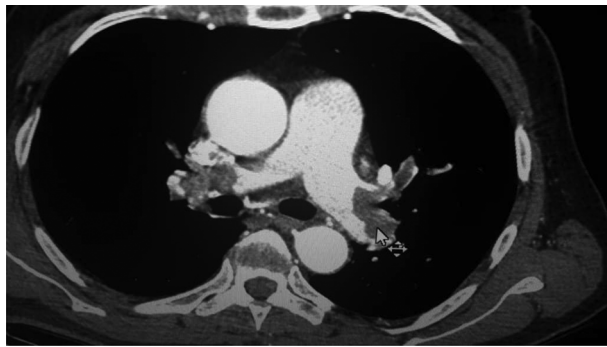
The CT angiography of the patient with pulmonary embolism; embolism is observed in the both left and right pulmonary arteries.
